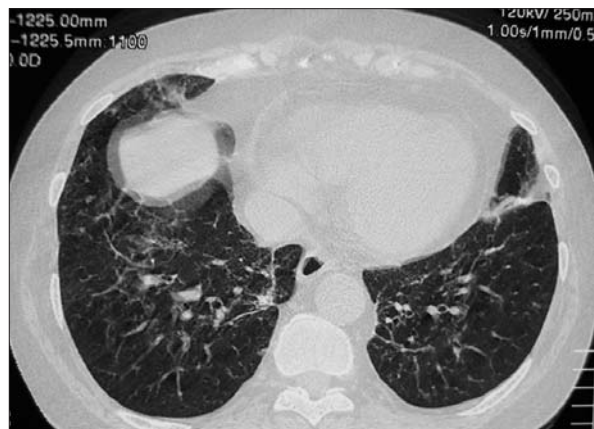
Chest CT (November 2003) no nodules and reduction of alveolar consolidation.
